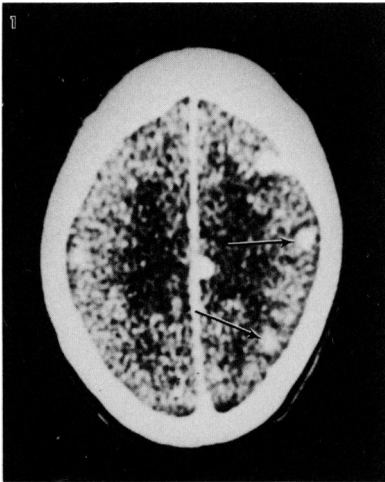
CT scan of brain showing several discrete contrast-enhancing brain lesions (*arrows*) initially thought to represent tumor metastatic to brain. Subsequent pathological examination, however, showed them to be of infectious origin (patient No. 1).
